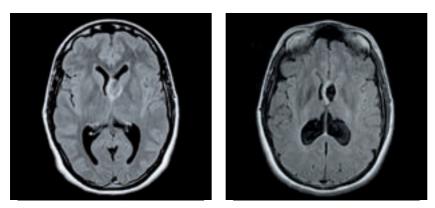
Pre-operative (left) and postoperative (right) axial FLAIR MR images are shown from patient that underwent purely endoscopic removal of a low grade tumor from the left foramen of Monro.*
